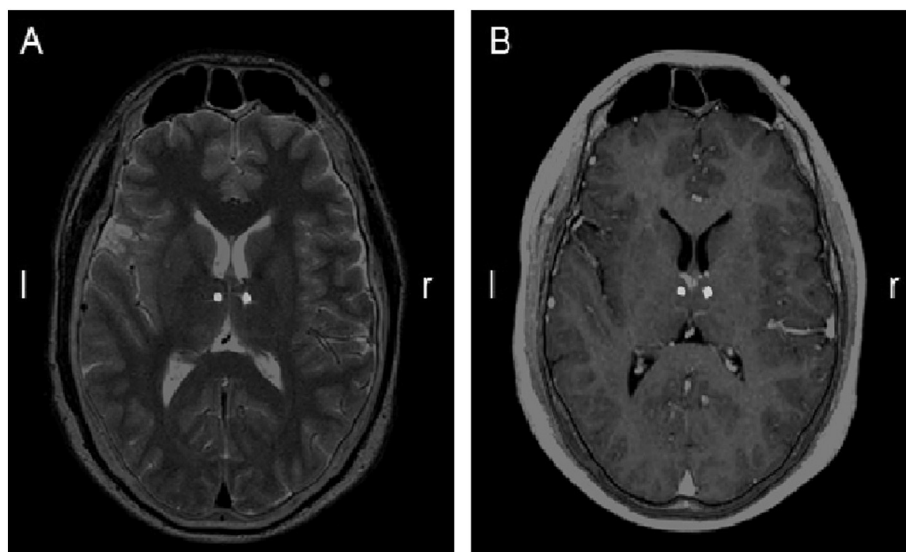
Pre-operative axial T2 (A) and T1 (B) 3 T magnetic resonance images fused with post-operative CT images showing bilateral DBS lead placement at the predefined anatomical target in the anterior nucleus of the thalamus (ANT).
